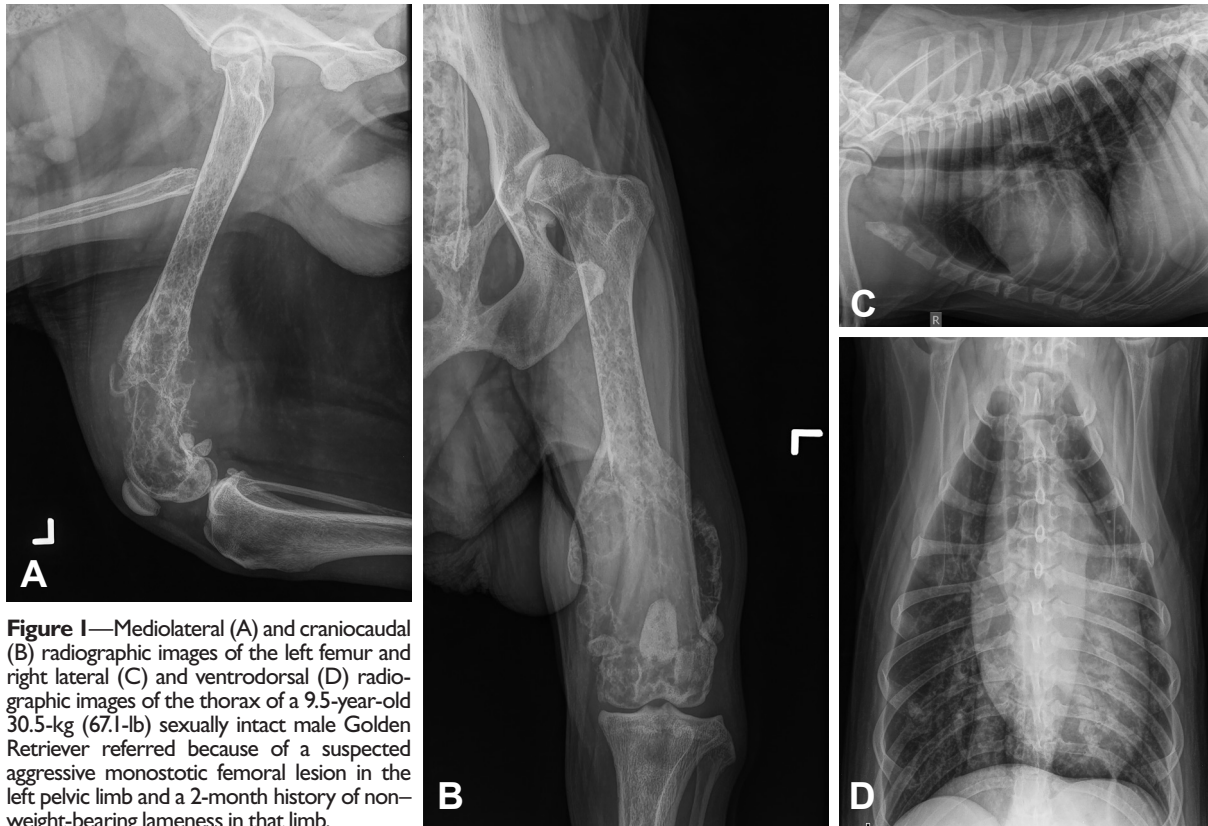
Mediolateral (A) and craniocaudal (B) radiographic images of the left femur and right lateral (C) and ventrodorsal (D) radiographic images of the thorax of a 9.5-year-old 30.5-kg (67.1-lb) sexually intact male Golden Retriever referred because of a suspected aggressive monostotic femoral lesion in the left pelvic limb and a 2-month history of non-weight-bearing lameness in that limb.
